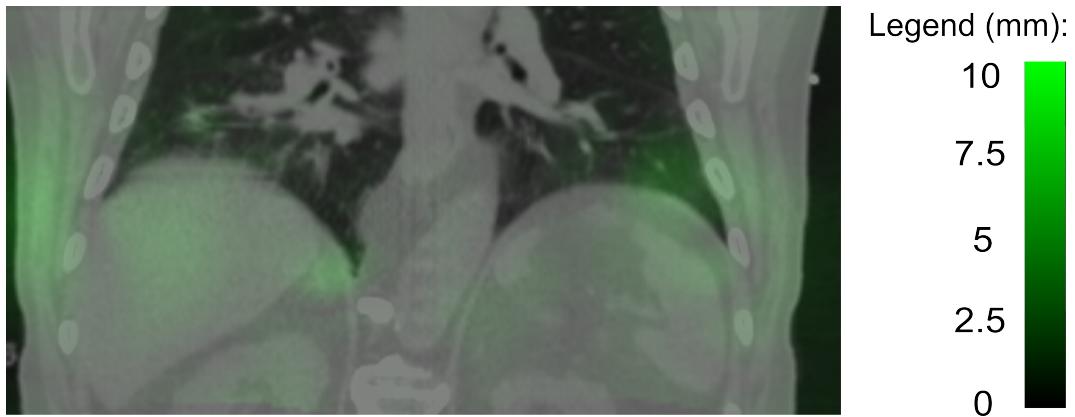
Image of the inverse consistency error (ICE) overlayed on a CT scan. The average value of displayed ICE is 1.0 mm with 0.8 mm standard deviation.
